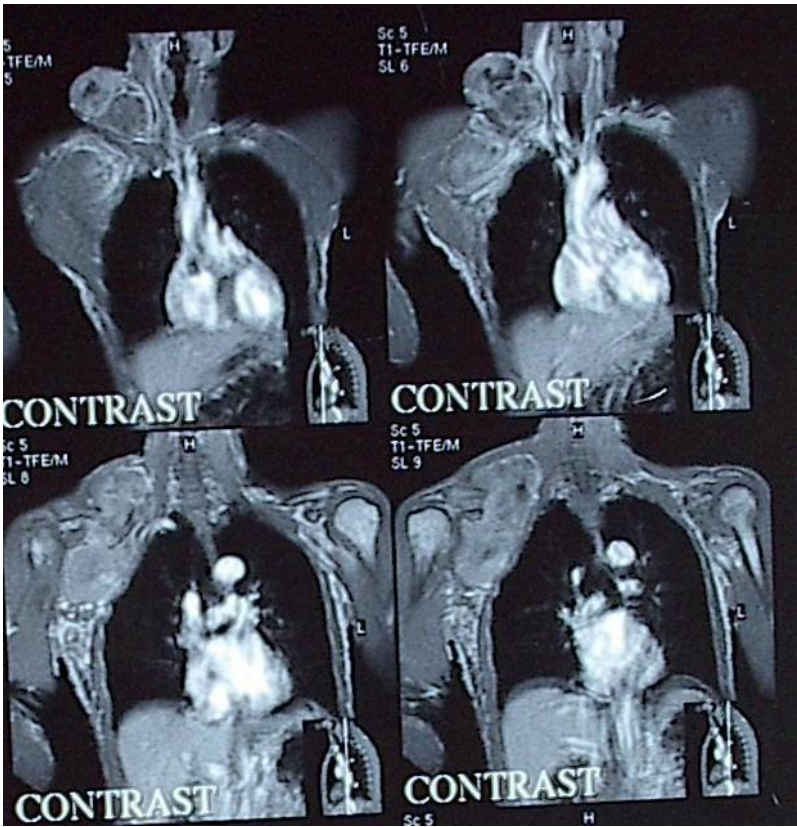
b: MRI of First Patient with Contrast
